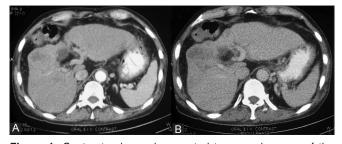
Contrast-enhanced computed tomography scan of the liver. Arterial phase image shows (A) hypodense exophytic lesion in segments five and eight of the liver, with minimal enhancement. Venous phase image shows (B) no washout or enhancement of the mass lesion in the portal venous phase
